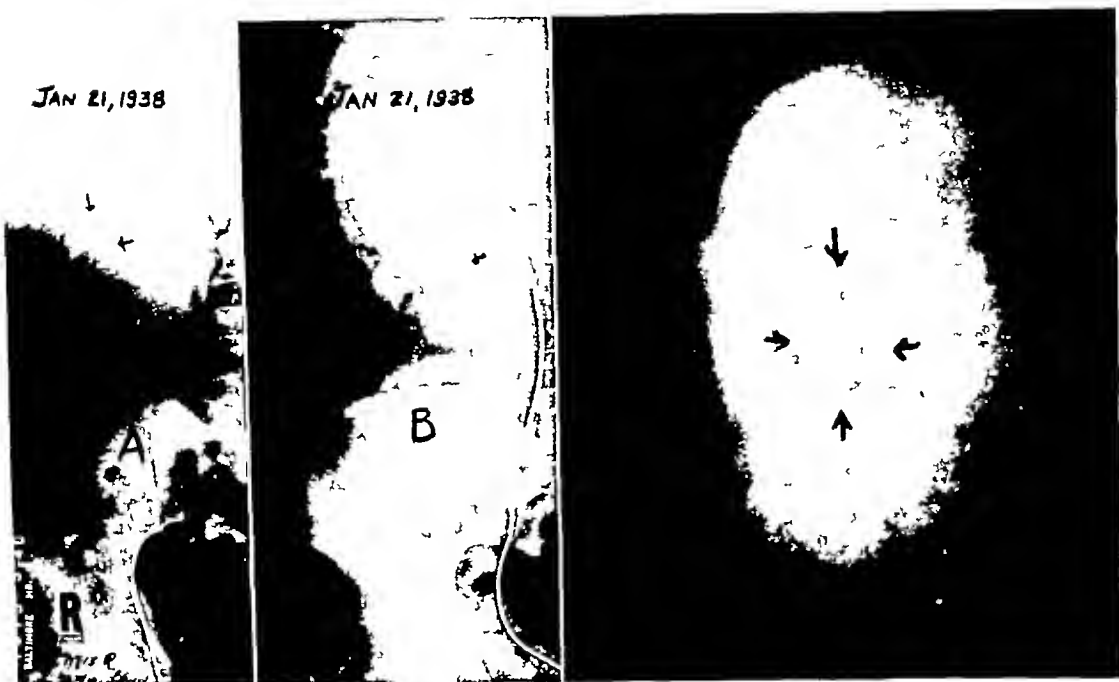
(left) Case XVII The area of calcification in the right kidney, observed in 1927, is present in the plain film (A) taken exactly 11 years later. There is no apparent increase in the size of the shadow. The right stereoscopic pyelogram (B) shows a marked dilatation of the pelvis and calices with distortion of the pelvis and lower calices by a tumor mass on the posterior surface of the kidney. The calcified area appeared to be in the central portion of the tumor mass.
